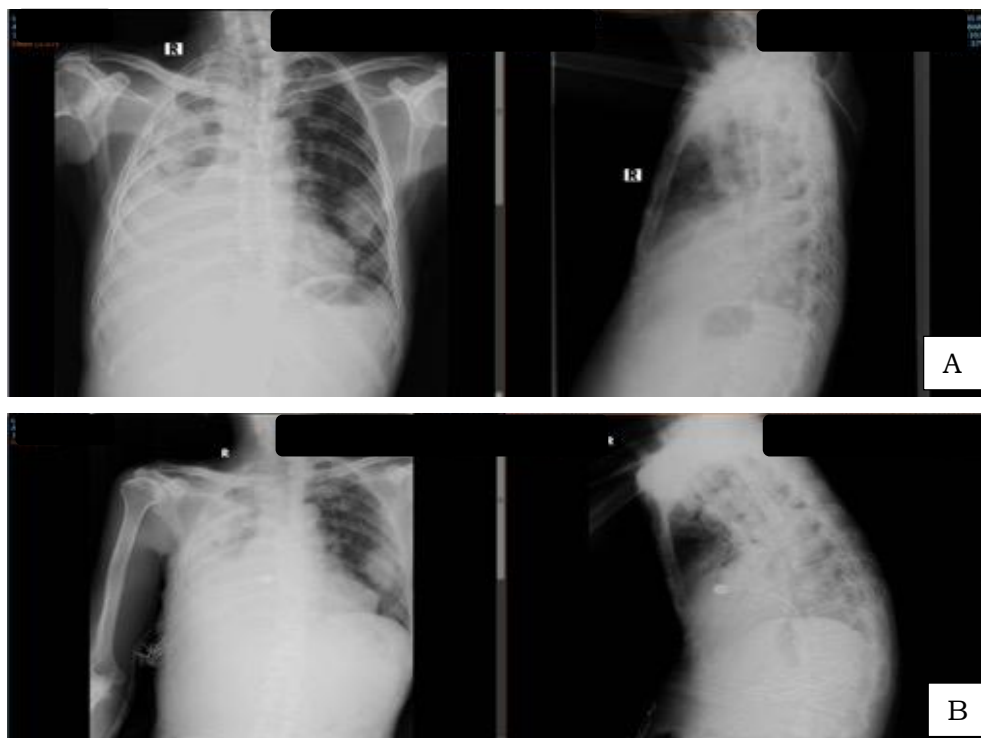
Chest X-ray imaging. (A) Pre-WSD insertion; (B) post-WSD insertion.
